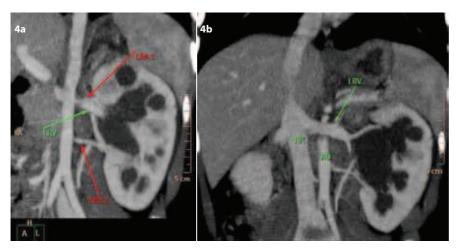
Contrast enhanced computed tomography (CECT) of upper abdomen (reconstructed images): a. Normal imaging of two left renal arteries, and b. normal imaging of left renal vein. No signs of thrombus or laceration of left renal vessels was identified. Of note, the inhomogenous spleen's enhancements during the early stage of IV contrast administration (pseudomas effect due to differential enhancement of the red and white pulp).
